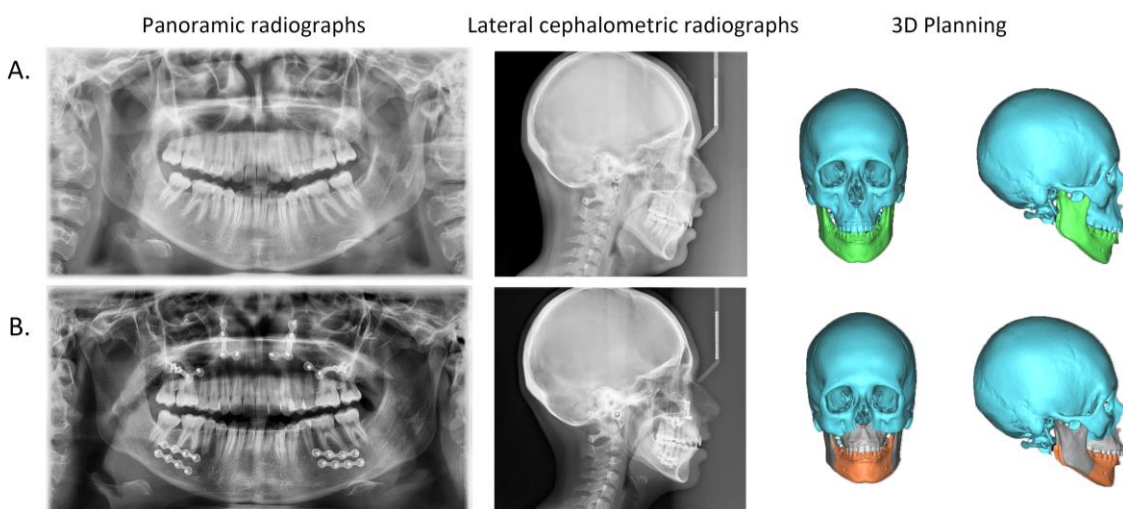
Panoramic and lateral cephalometric imaging with three-dimensional (3D) virtual modeling. A. Preoperative radiographs and virtual model. B. Two-year postoperative radiographs and 3D virtual plan.
